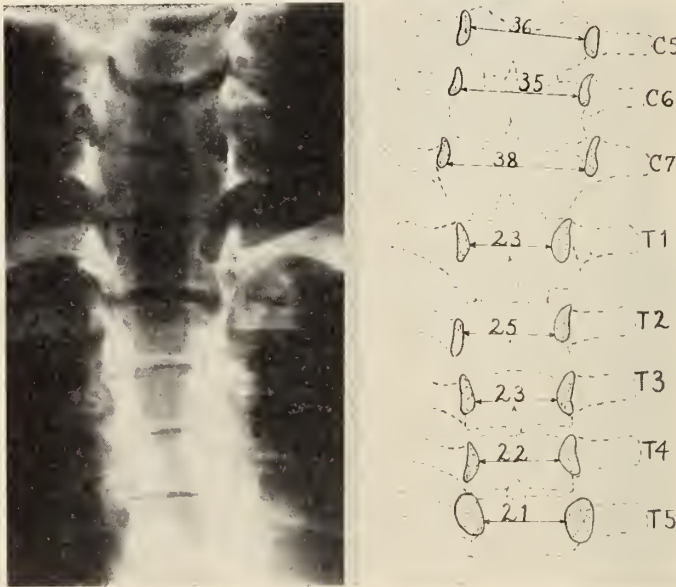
X-ray showing enlargement of the interpedicular spaces and atrophy of the pedicles of the three lower cervical and four upper thoracic vertebrae in a case of large extradural and intradural lipoma.
